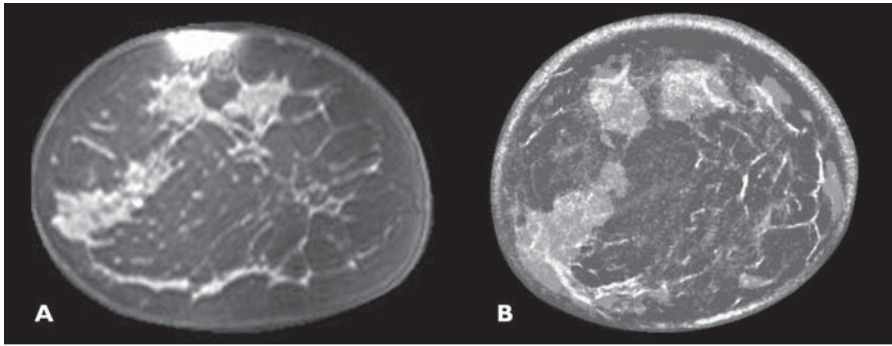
45-year-old woman with scattered breast density. A and B, Coronal T1 fat-saturated enhanced MR image (A) and fused ultrasound tomography image (B) show similar anatomic distribution of fibrous bands and overlying fibroglandular tissue. In B, dark gray corresponds to fat and semitransparent lighter gray represents denser fibroglandular tissue with underlying thin white fibrous bands.
